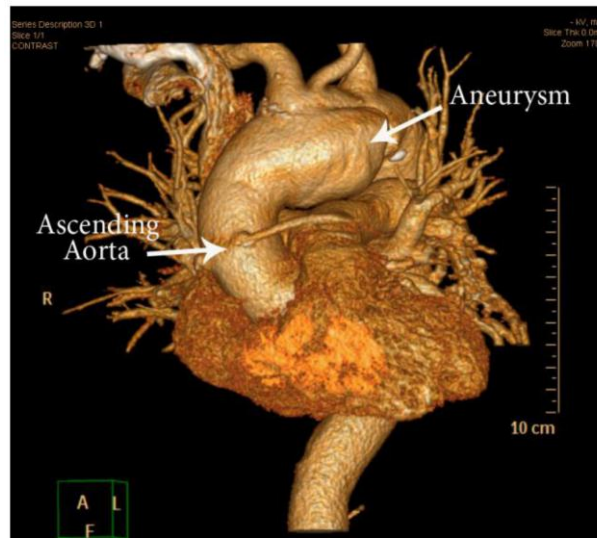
CT angiography of ascending aorta showed the aneurysm in the site of cannulation of the ascending aorta during coronary artery bypass graft.
